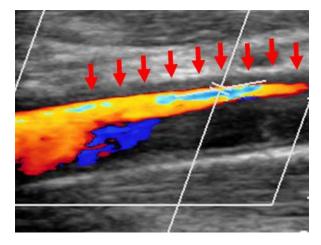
Duplex sonography of the right carotid artery showing the dissection with diminished flow (arrows).
